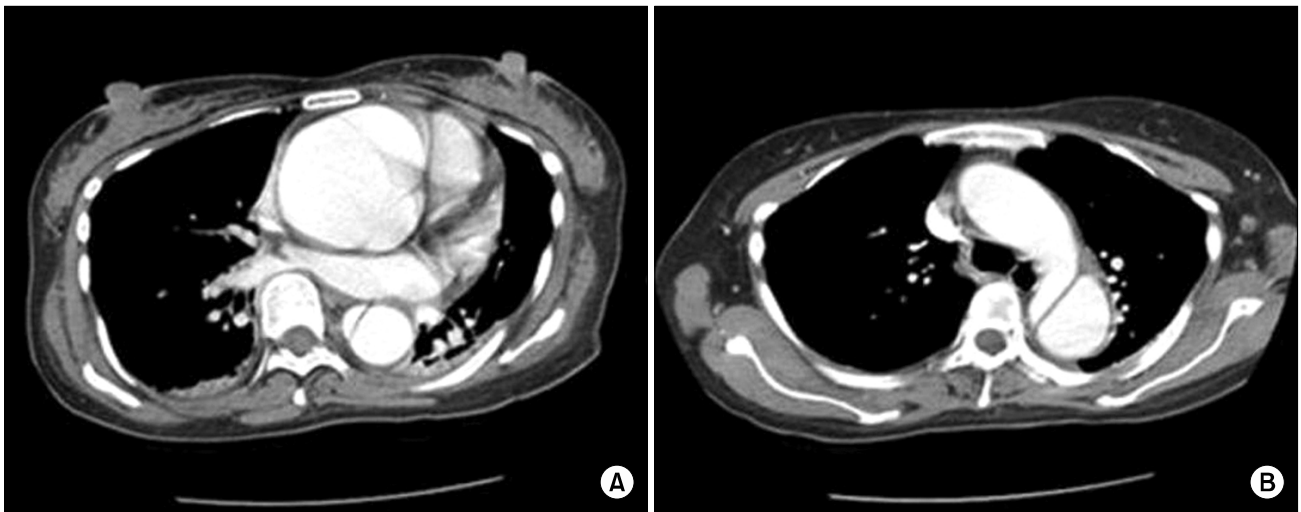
Computed tomography. (A) Huge dilatation of the aortic root with descending aortic dissection. (B) Normal aortic arch.
